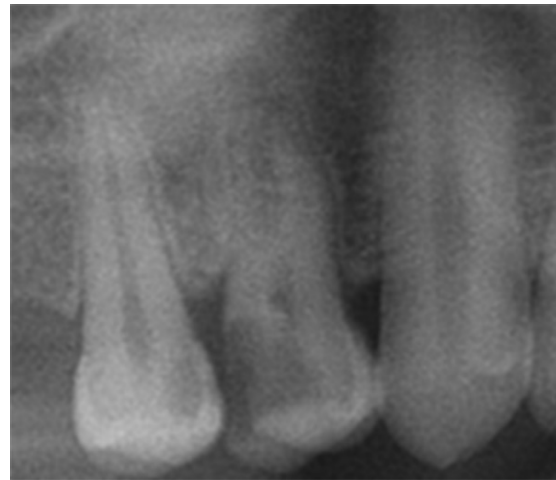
Periapical radiograph, showing the complex root morphology of the maxillary first premolar suggesting the existence of three root canals.
